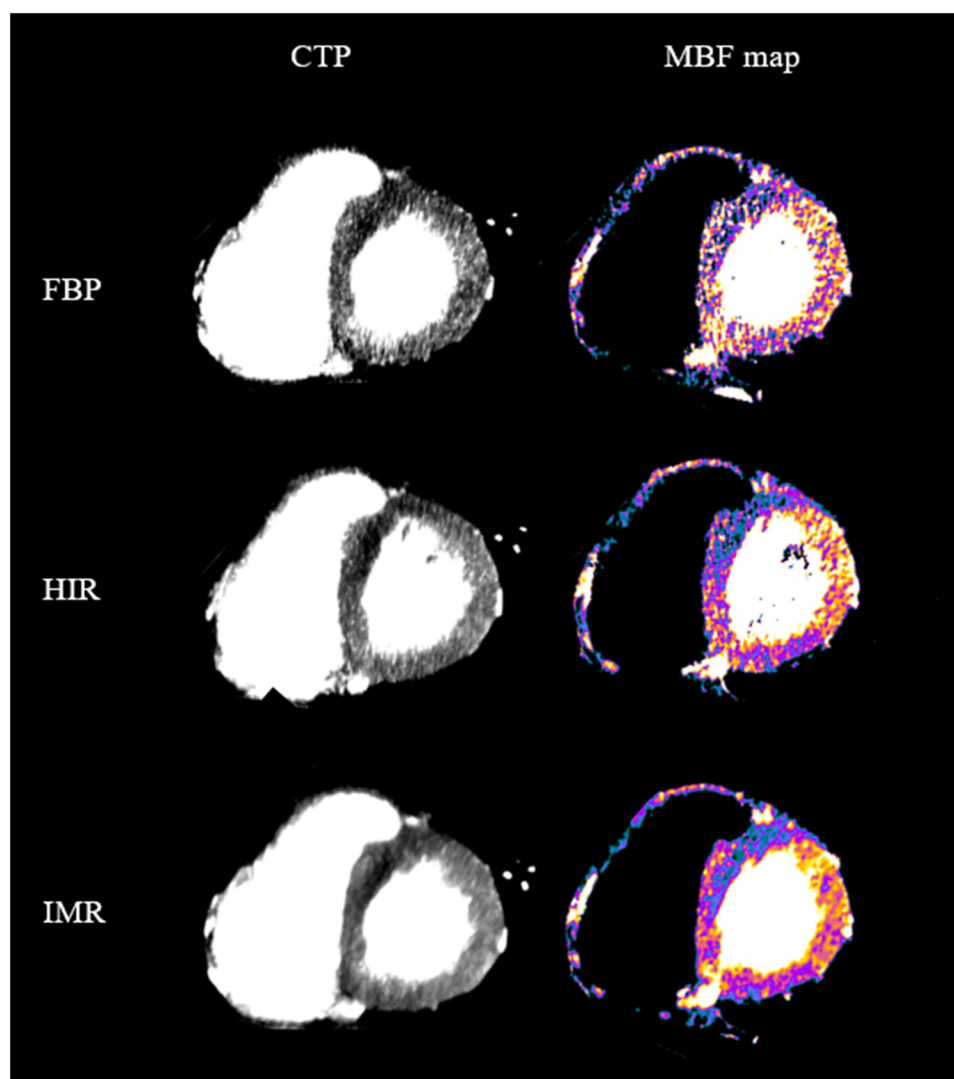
Computed tomography perfusion (CTP) images and myocardial blood flow (MBF) maps reconstructed using three different techniques: filtered back projection (FBP), hybrid iterative reconstruction (HIR), and model-based iterative reconstruction (IMR). IMR provides the lowest image noise in CTP images compared to FBP and HIR.
